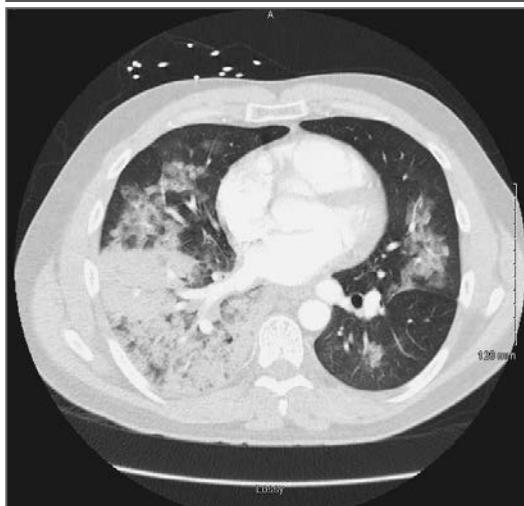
CT of the Chest 1 Day after Presentation.
